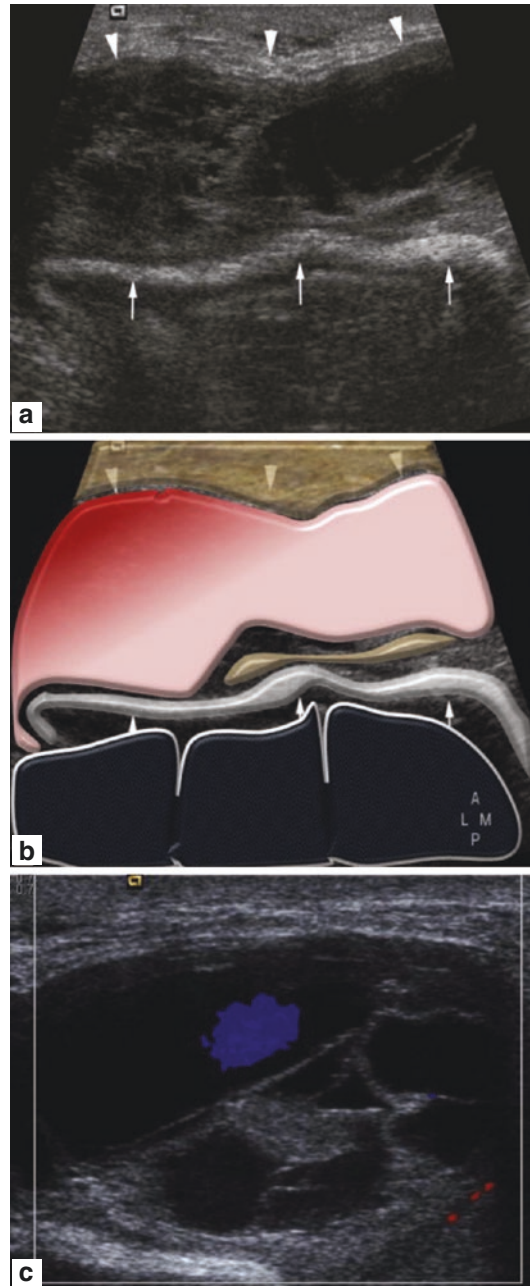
Left inguinal mass after direct hernia repair, transverse sonograms. (a, b) A well-defined hyperechoic linear structure (arrows) lies on the deep aspect of the inguinal canal and has the typical appearance of a mesh placed over the posterior inguinal wall. However, filling the canal is a lobulated, predominantly heterogeneous soft tissue mass consistent with a postoperative hematoma (arrows). (c) Color Doppler shows no flow within the solid areas. With permission from: Practical Musculoskeletal Ultrasound [Philip Robinson]. Disorders of the Groin and Hip: Groin Pain
